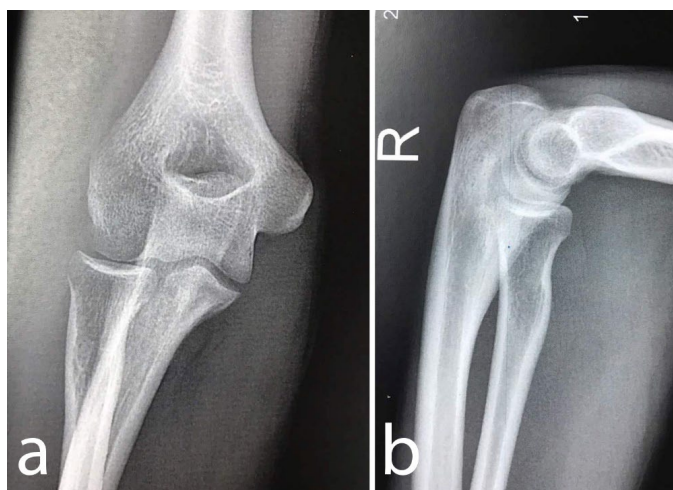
Anteroposterior (a) and lateral (b) X-rays of the affected elbow show no pathological findings
